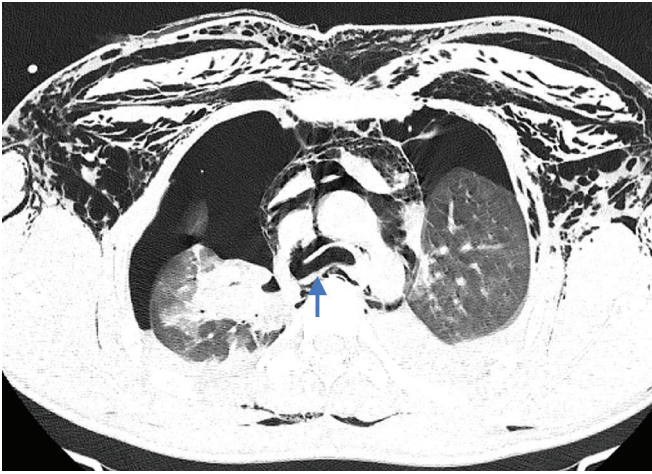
CT chest at the level of carina before insertion of intercostal drains, arrow showing site of tracheal laceration
